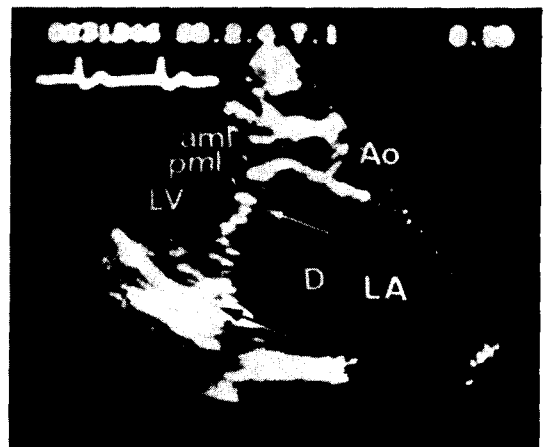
Real-time two-dimensional echocardiogram in the long-axis view showing extremely dilated left atrium (LA) and the inward bending position of the posterobasal wall of the left ventricle (LV) in diastole. Ao, Aorta. aml, Anterior mitral leaflet. pml, Posterior mitral leaflet. D, The length of the bending segment.
